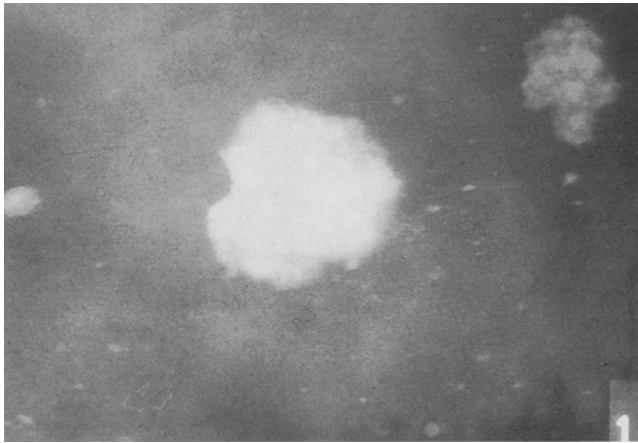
20 × magnification of cement particles by direct X-ray imaging
